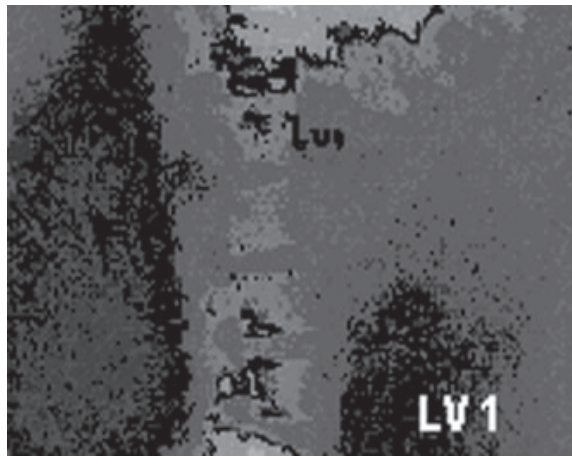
Plain Radiographs showing compression fracture
